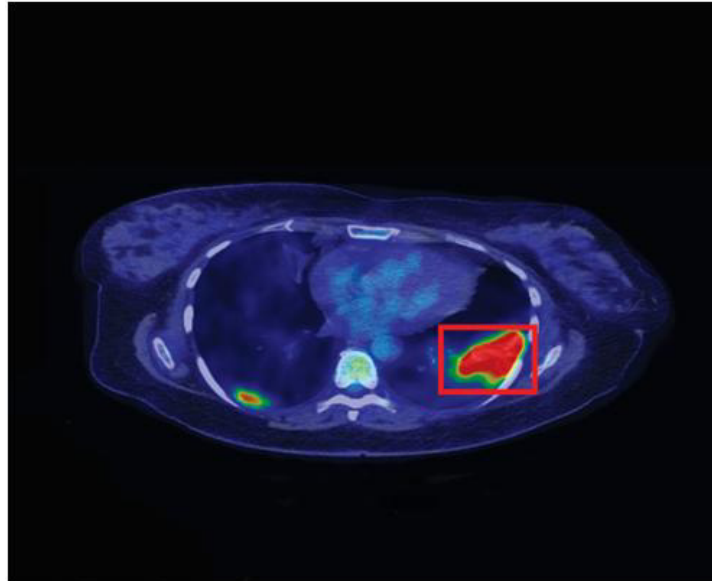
The PET-CT examination revealed — pulmonary frosted-glass opacities and interstitial lung lesions, isolated and confluent isolated and confluent overlapping with alveolar foci, visible in both lung fields (predominantly the right side).
